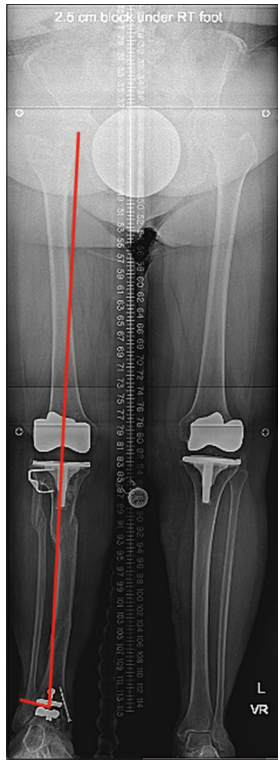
Standing 52-inch long leg radiograph 30 weeks status post right total ankle replacement with mechanical axis drawn to highlight the ankle valgus tilt, evidenced by an abnormal lateral distal tibial angle measuring 82°. Also apparent is the tibial diaphyseal malunion
